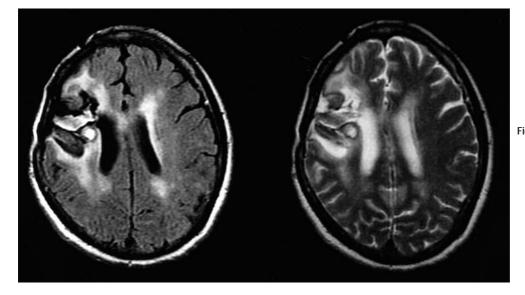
The brain MRI of Patient 5 with recurrent LICH revealed presence of ICH combined with hemosiderin and brain tissue loss change in the right side fronto- temporal and parietal region. Post-craniotomy in the right side fronto-parietal region was noted.
